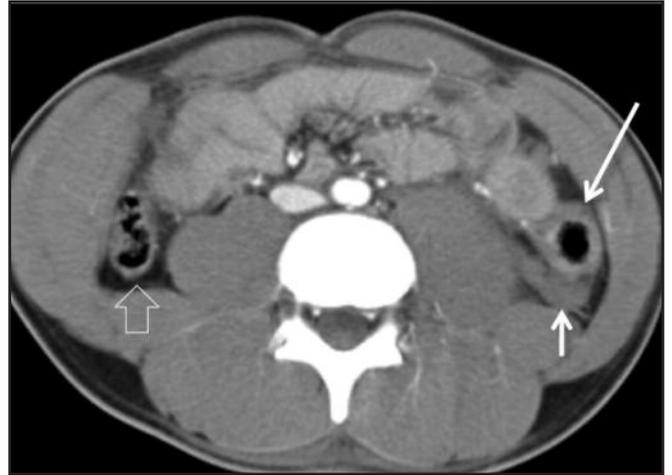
CT abdomen of a 23-year-old patient who was trapped in a lorry following a motor vehicle accident. Injury to the descending colon was suspected in view of fluid collection at the left retroperitoneum (short arrow) and a thickened colonic wall (long arrow). Compare to the normal fat density surrounding the right ascending colon (open arrow). Serosal tear of the descending colon was proven at surgery.
